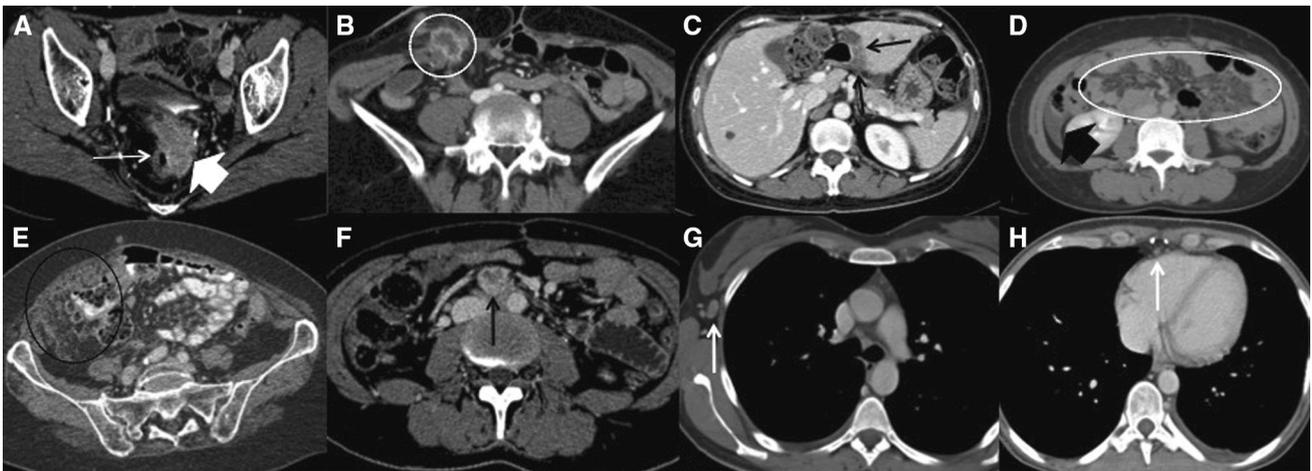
CT scan detection of ovarian cancer recurrence. An axial post-contrast CT image (A) shows pelvic recurrence (white arrowhead) after primary surgery on the vaginal vault, with infiltration of the sigmoid colon (white arrow). Other post-contrast CT images show recurrent implants on the ileostomia (B; white circle) and on the liver serosa (C; black arrow). A
